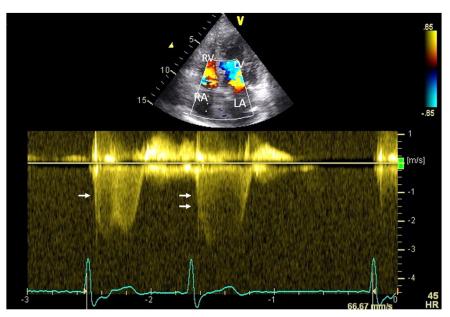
Transthoracic echocardiography, apical 4-chamber view with CW Doppler interrogation across the TV, demonstrates TR. In the first cycle (*single arrow*), there is a second TR jet appearing with retrograde P wave, which is absent in the second cycle (*double arrow*), which is a sinus beat without retrograde P wave. *LV*, Left ventricle.
